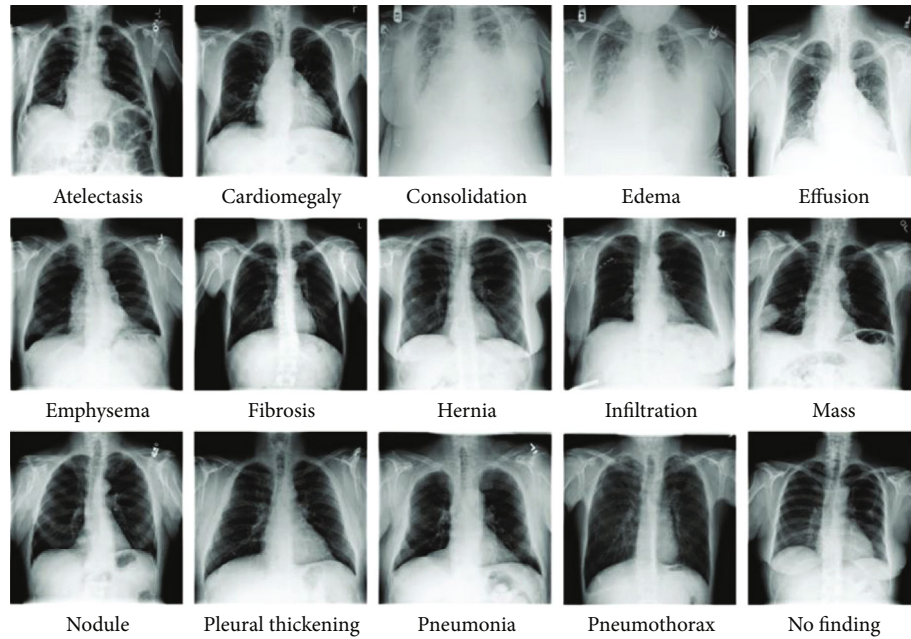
Chest X-ray images, with their respective labels, belonging to the ChestX-ray14 data set.
